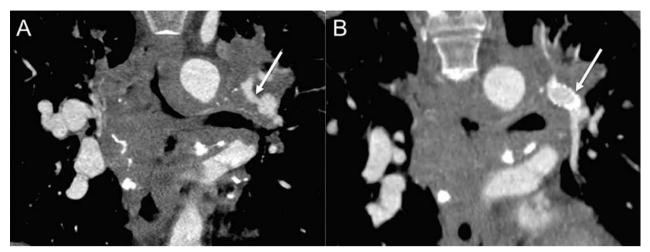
Coronal CTA images before (A) and after (B) stent placement. Severe stenosis of the left pulmonary artery is visible on the initial study (arrow, A) as a result of compression from confluent mediastinal and hilar lymphadenopathy. A follow-up CTA two years after stent placement shows that the stent remains widely patent (arrow, B) with improved perfusion of the left lung
